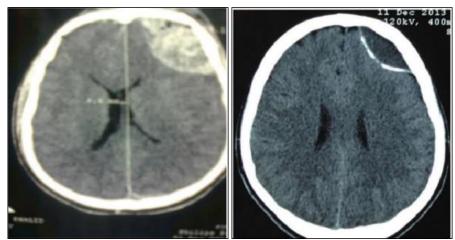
Pt. 26 yrs female presented to SNMC emergency with GCS 13 due to FFH. (a) EDH volume 35.8 ml in left frontoparietal region (b) CT repeated after 2 days showing resolving hematoma. (c) CT repeated after 22 days hematoma resolved further with improving GCS
